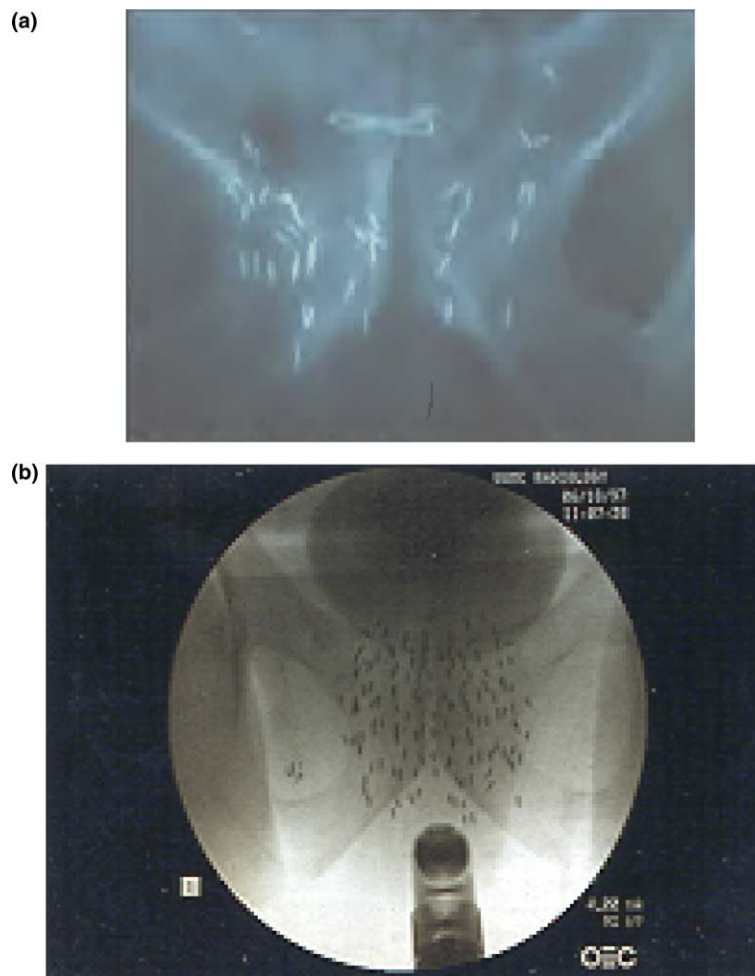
(a) Placement of brachytherapy seeds via traditional freehand retropubic approach. (b) Placement of seeds via modern transperineal approach using transrectal ultrasound (seeds identified using fluoroscopy).
